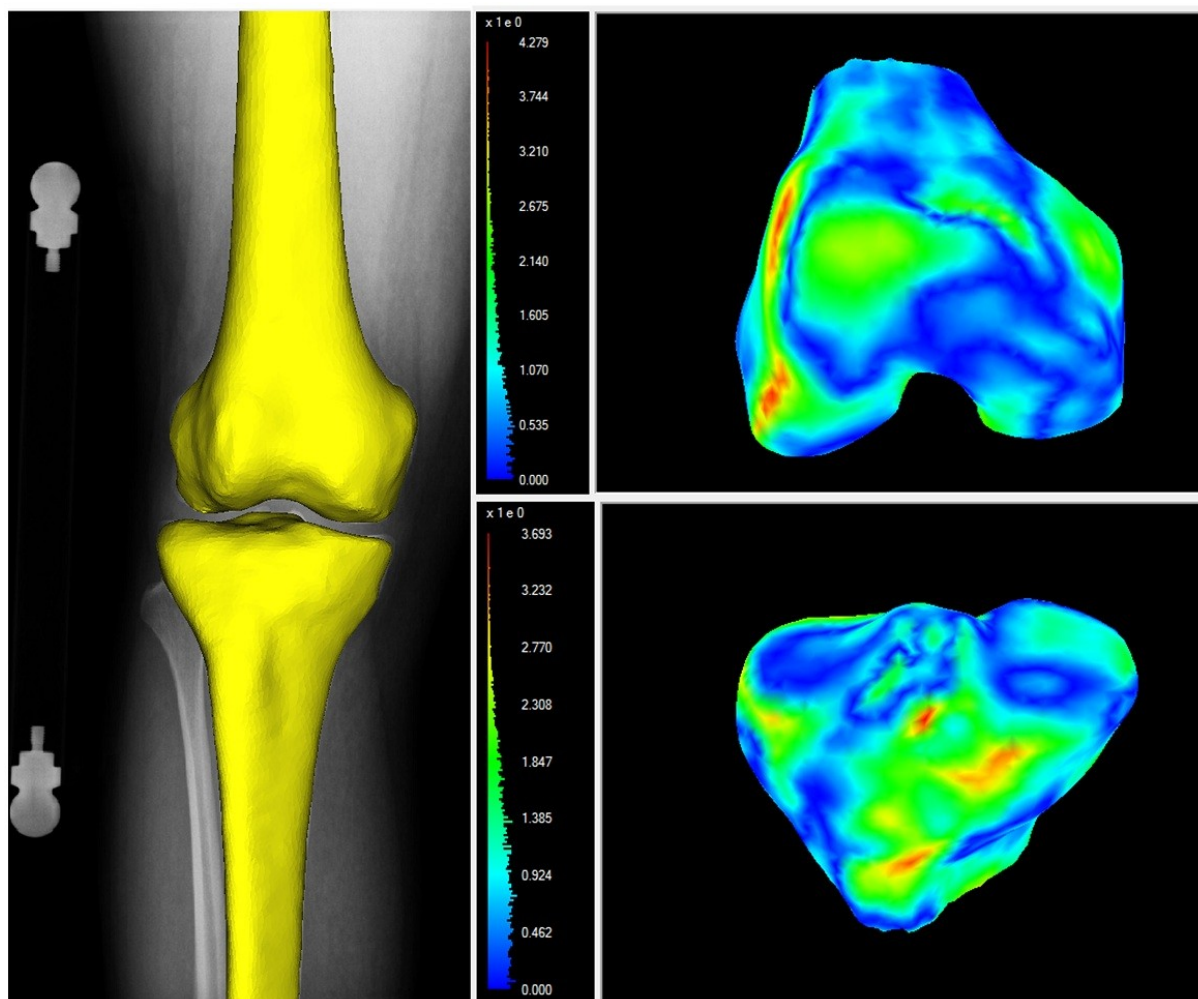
Reconstruction of patient-specific models of a knee joint from a roughly calibrated X-ray radiograph. Left: the reconstructed models (both distal femur and proximal tibia) superimposed on the X-ray image with calibration object; Top-right: the color-coded reconstructing error distribution for the distal femur; bottom-right: the color-coded reconstructing error distribution for the proximal tibia.
